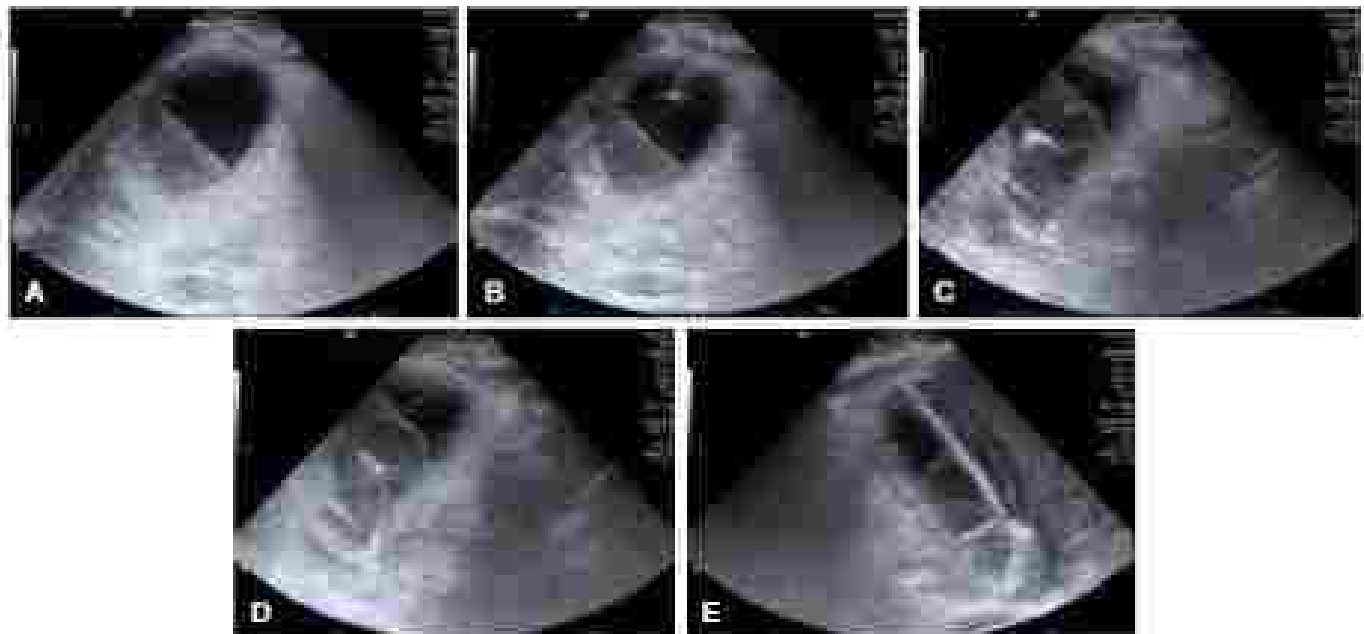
Ultrasound guidance of cholecystostomy tube. (A) Gallbladder is visualized. (B-C) Gallbladder is accessed with a Fehr needle. (D-E) Pigtail catheter is placed into the gallbladder lumen.
